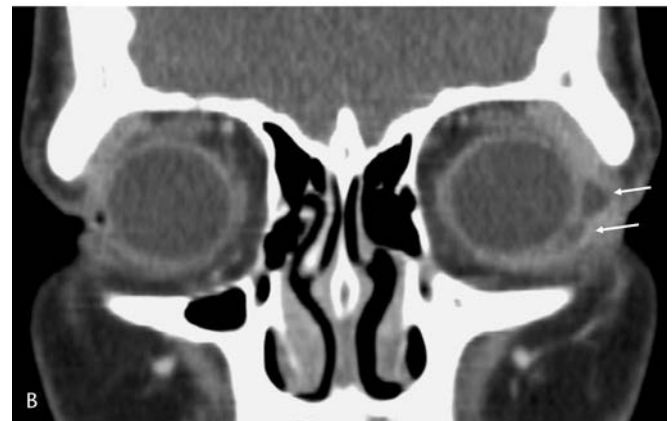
(A) Axial and (B) coronal computed tomography orbits with contrast showing an abscess cavity lateral to the left globe.
